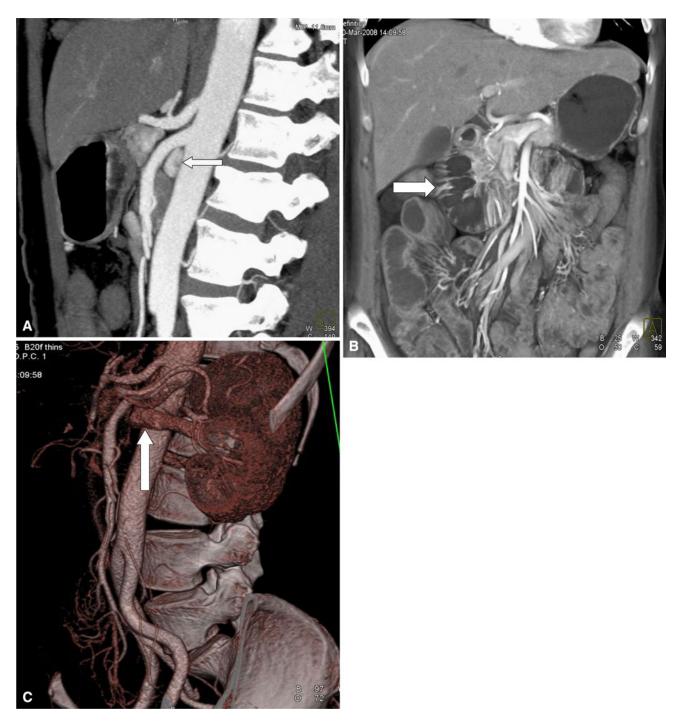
A 51-year-old female with chronic abdominal pain. Sagittal MIP CT image (A) demonstrates narrowing of the aortomesenteric angle and distance, with compression of the duodenum (*arrow*). Coronal volume-rendered image (B)
